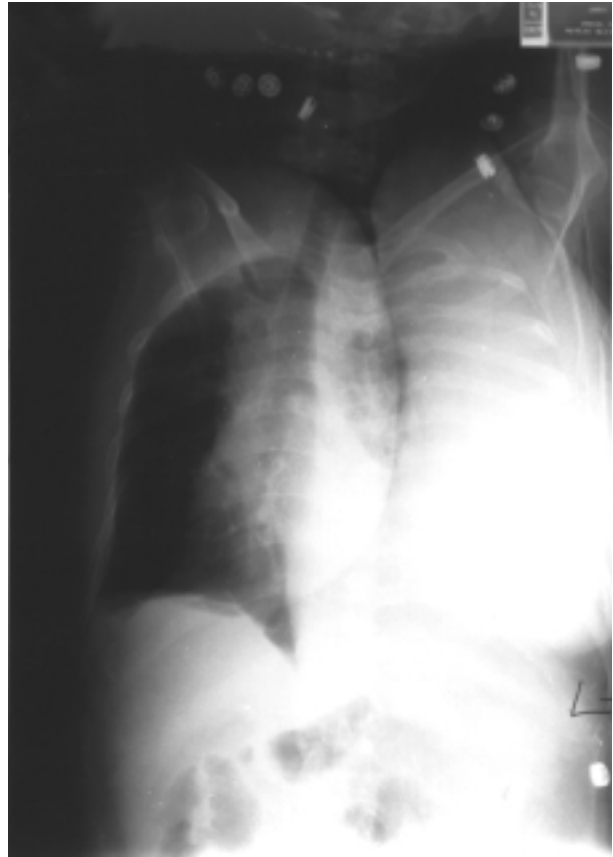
Repeat chest radiography of the patient performed several hours after hospital admission for left pleural effusion demonstrates increasing effusion.
